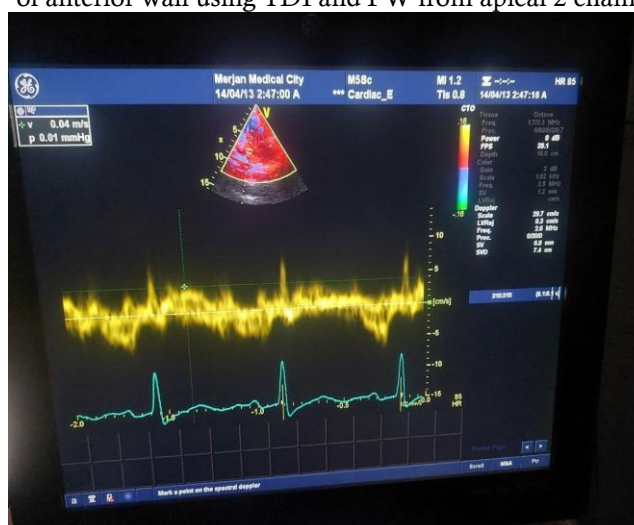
measurement of $S^{\wedge}$ of inferior wall using TDI and PW from apical 2 chamber view
